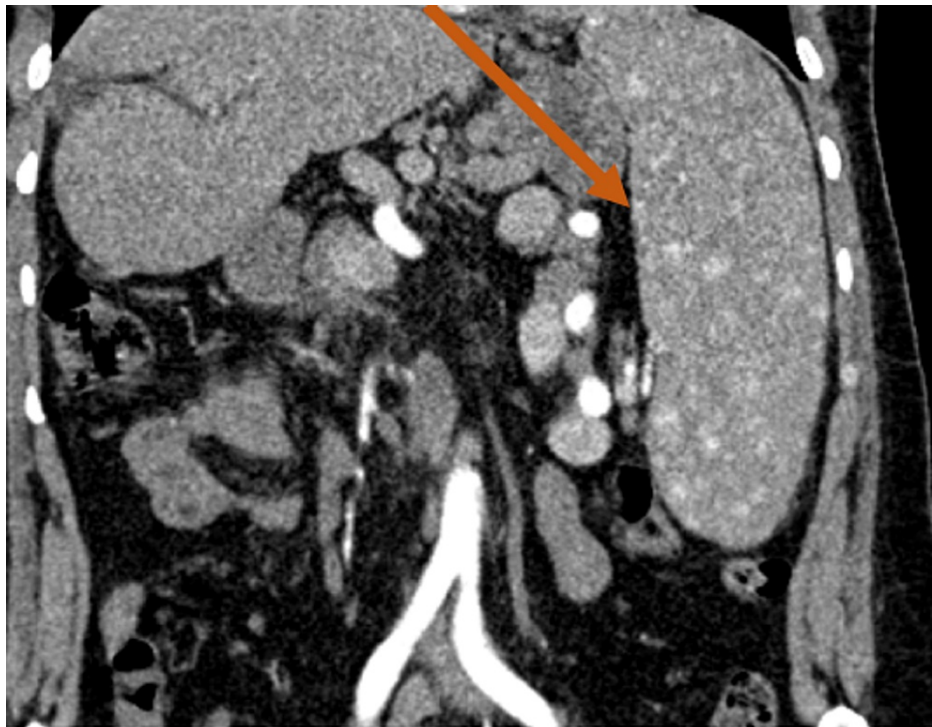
Coronal abdominal CT scan view in arterial phase after iodine injection
